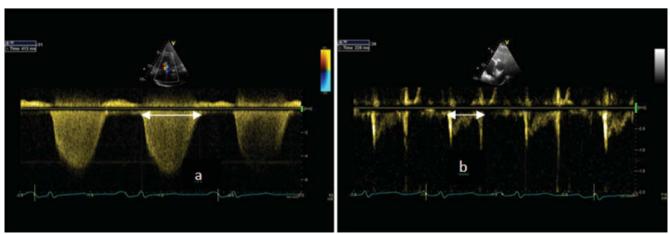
Spectral Doppler recordings of CW of the tricuspid regurgitation jet in order to measure the interval "a" between the start and end of trans tricuspid flow (Figure 1), and PW of right ventricular outflow in order to measure interval "b", the right ventricular ejection time (Figure 2).
